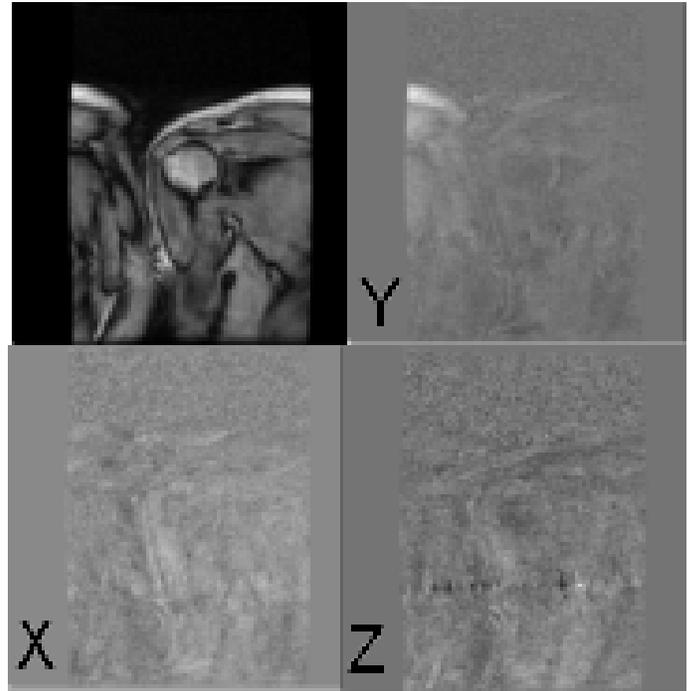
Four sample images of CPC-MRI. Upper left is the magnitude image where the geometry of the supraspinatus can be seen over the humeral head. The three other images show a gray-scale representation of the velocity data for the X (horizontal) and Y (vertical) and Z (in and out of plane) velocities.
